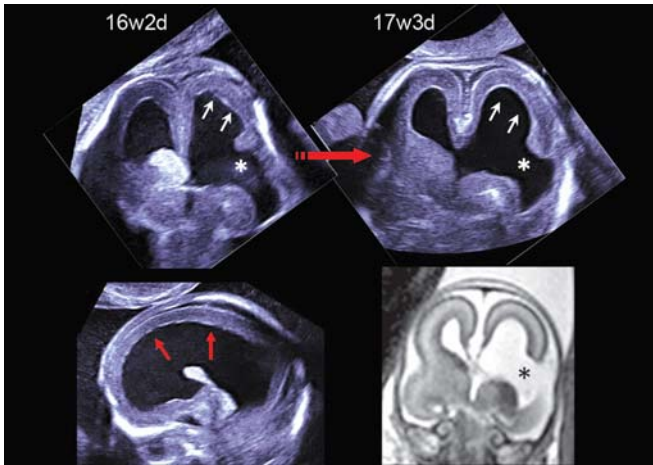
Early intracranial hemorrhage/porencephaly case (upper figures) dedicated transvaginal high-frequency sonography detected the subtle change of ventricular wall between 16 and 17 weeks of gestation (arrows). (Left lower) ventricular wall is irregular and hyperechogenic (red arrows), indicating intraventricular hemorrhage. (Right lower) MR image of the same fetus at 20 weeks. Asterisks indicate the missing brain (porencephaly) because of early brain hemorrhage
